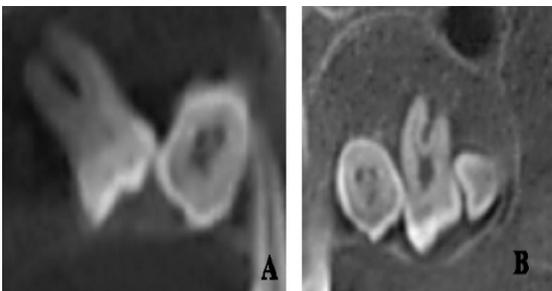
Cone-beam computed tomography images of the maxilla, showing (A) two impacted molar teeth in the posterior region of the right quadrant and (B) three molar teeth in the left quadrant.
